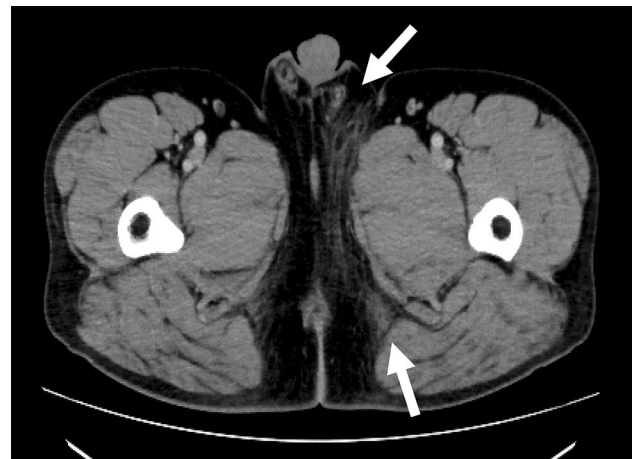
A computed tomography scan of the lower abdomen and pelvis showing pathologic Fournier's gangrene. Evidence of fat stranding and gas (arrow) in the perineum, the scrotum, and the left inguinal region
